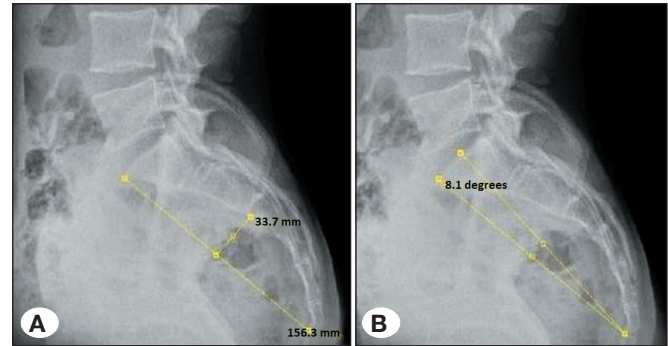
Lateral lumbosacral radiograph of a 19-year-old man with lumbarization. The measurement of the ATA1 and ATA2 are shown in (A) and (B), respectively.
